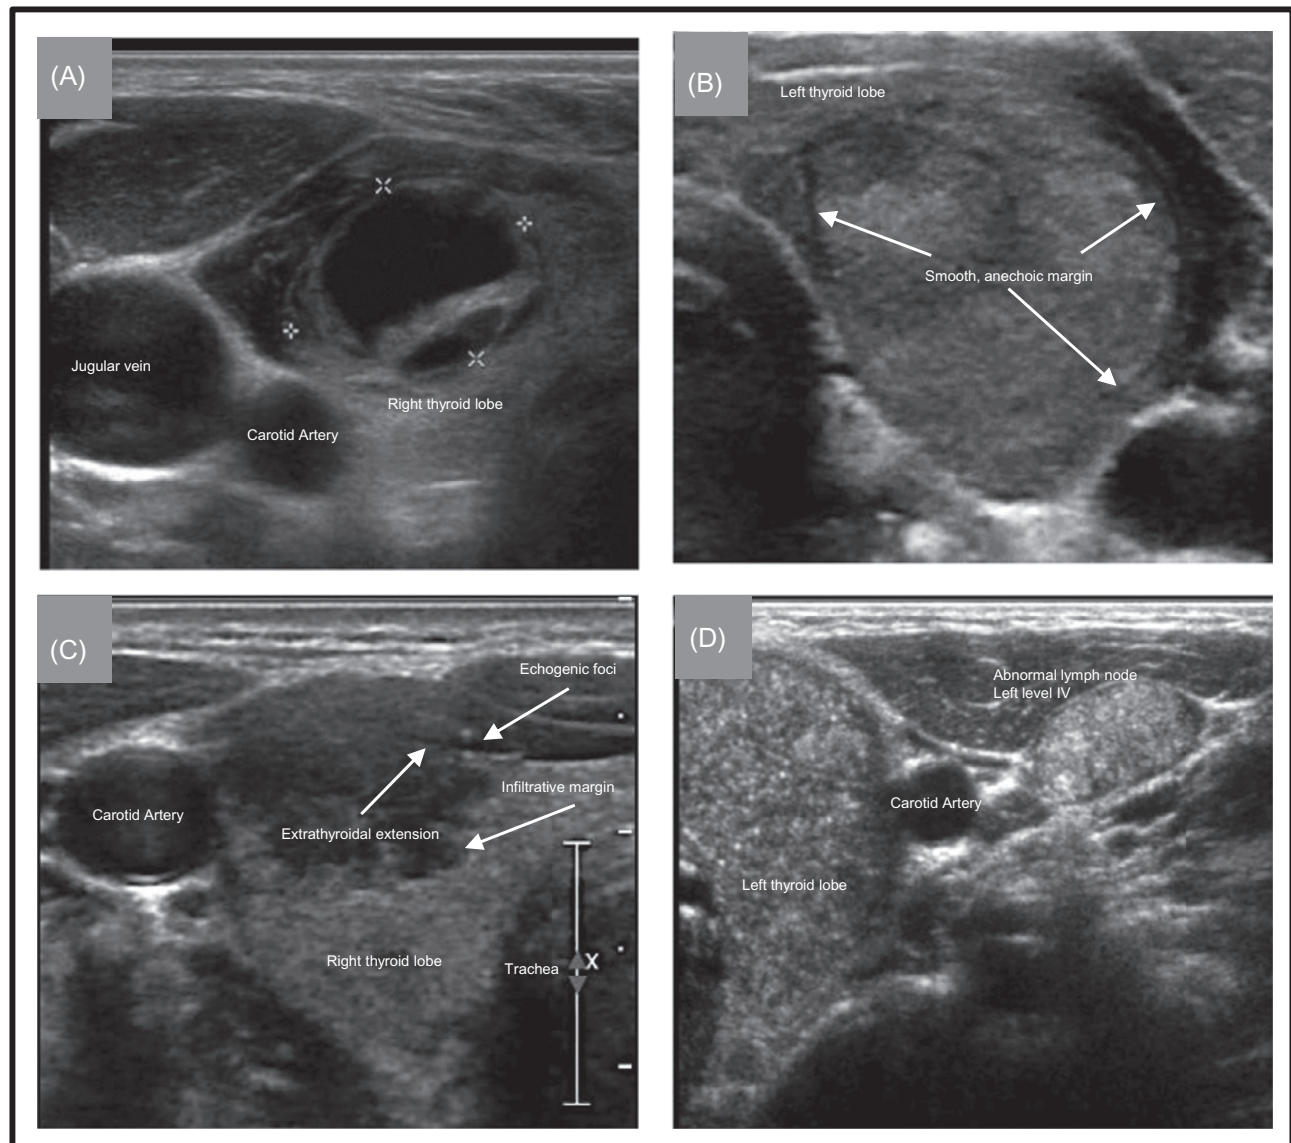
Representative images of thyroid nodules depicting different features used in the Thyroid Imaging Reporting and Data System (TI-RADS). (A) Complex, mixed solid-cystic nodule (>80% cystic), solid portion is isoechoic with smooth margins, no echogenic foci, with small solid not taller than wide, smooth margins, and no echogenic foci (TI-RADS 2). (B) Solid, iso- (larger, posterior portion) and slightly hypoechoic (smaller, anterior area) nodule, not taller than wide, with smooth margins, and no echogenic foci (TI-RADS 3). (C) Solid, very hypoechoic, not taller than wide, lobulated, invasive margins with evidence of extrathyroidal extension (arrows), and several echogenic foci (TI-RADS 5). (D) Solid, hypoechoic, diffusely invasive lesion with too numerous to count echogenic foci (TI-RADS 5). An abnormal lymph node is noted in lateral neck with similar ultrasound features to the primary tumor.
